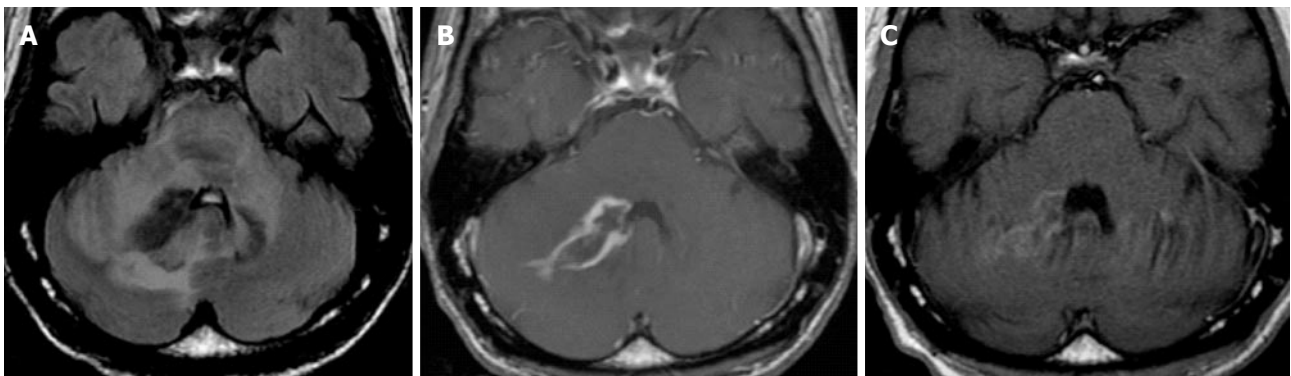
Immune reconstitution inflammatory syndrome and progressive multifocal leukoencephalopathy. HIV + JC virus, irregular antiretroviral therapy, with confusion and right sided weakness. Axial FLAIR (A) and axial post contrast (B) show abnormal signal in the bilateral MCP, greater on the right with associated enhancement; Axial post contrast (C) 2 mo after treatment with steroids and antiretroviral therapy show significant improvement of abnormal enhancement. IRIS might or might not be associated with an infectious process, in this case the abnormal enhancement in a patient with positive JC virus lead to the suspicious of a superimposed neoplastic process (lymphoma), other fungal or bacterial infection. Ultimately, the response to steroid gives the diagnosis of IRIS. IRIS: Immune reconstitution inflammatory syndrome; MCP: Middle cerebellar peduncles; HIV: Human immunodeficiency virus.
